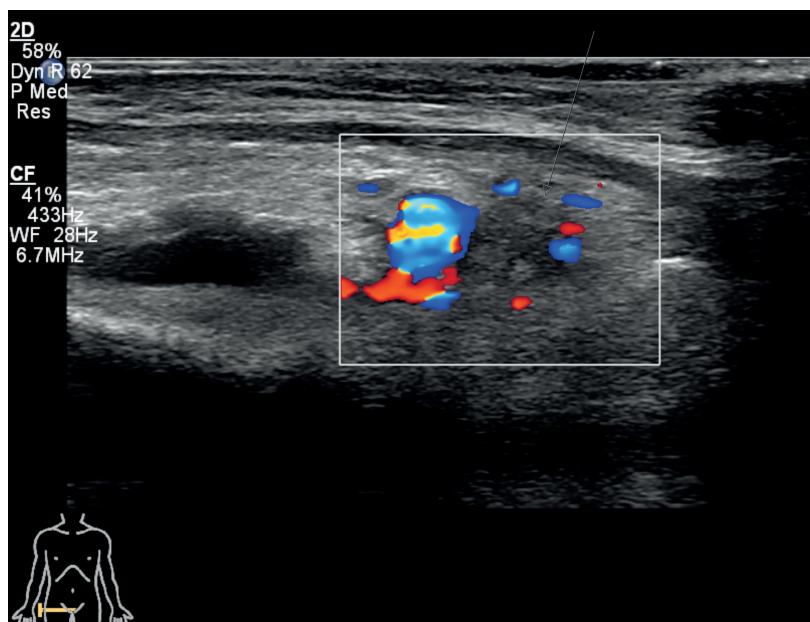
Ultrasonography of femoral vein with a thrombosis.
